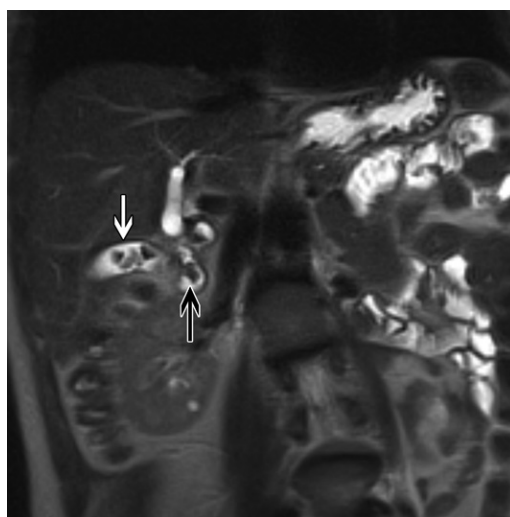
Cholelithiasis in a 44-year-old woman with Crohn disease. Coronal T2-weighted fat-saturated MR image shows multiple gallstones (white arrow) in a partially contracted gallbladder, with stones extending into a dilated cystic duct (black arrow).
